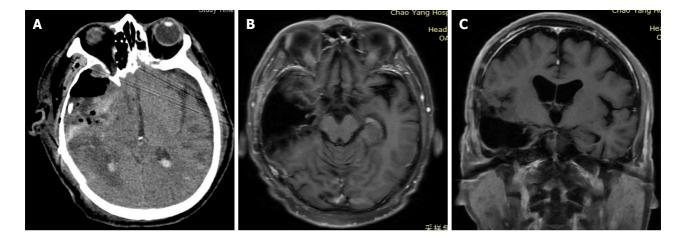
Postoperative neuroimaging. A: Postoperative head computed tomography showed a small amount of bleeding in the surgical cavity and the midline return; B and C: Enhanced magnetic resonance imaging performed at 6 months postoperatively revealed no definitive sign of recurrence.
